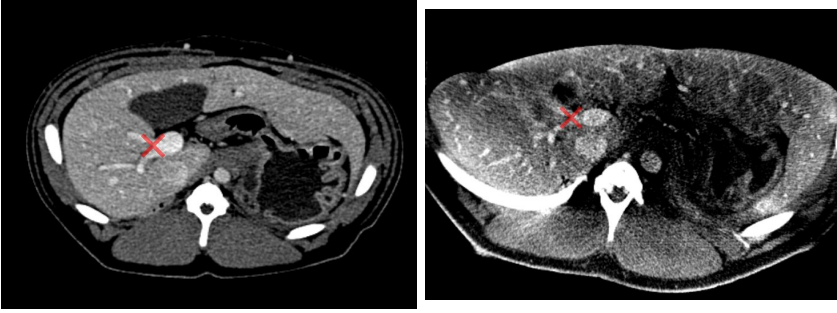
One can see the preoperative CT (on the left) and the C-arm 3D acquisition (on the right). The bifurcation of the portal vein we use to refine the translation is highlighted with a red cross.
